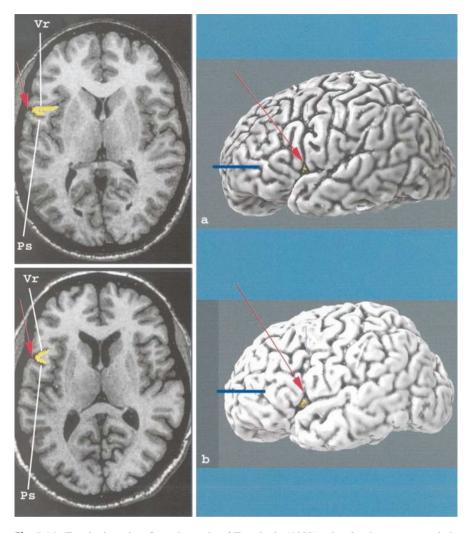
Two brains taken from the study of Tomaiuolo (1999), whereby the pars opercularis (*yellow area*) is hidden beneath the cortical surface. In these cases the ramus ascendens and the inferior precentral sulcus cannot be distinguished on the surface of the brain (*red arrow*). They are, however, easily identified on axial MRI images. *Vr* vertical (or ascending) ramus, *Ps* inferior precentral sulcus (Figures taken from Tomaiuolo, 1999 [33])
